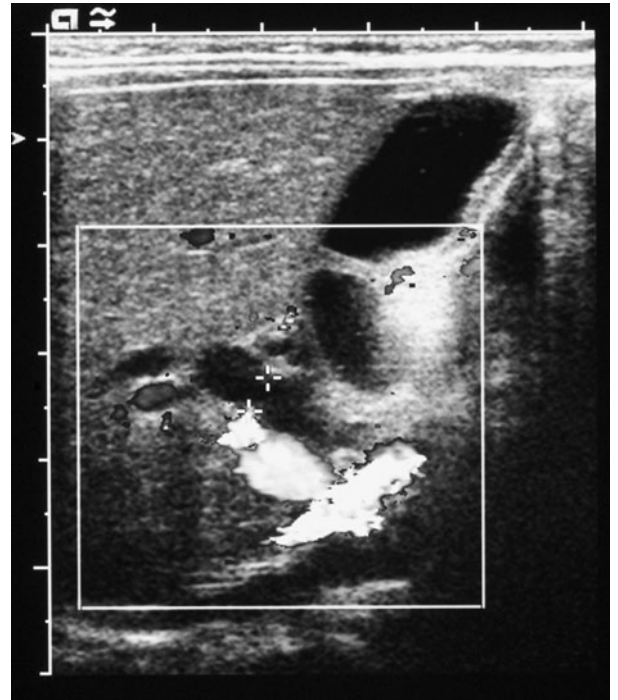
Ultrasound bile duct dilatation. US reveals dilatation of the common bile duct (calipers) in this neonate with gallstones. Color Doppler imaging is often used as in this instance to identify vascular structures separate from the bile duct.
